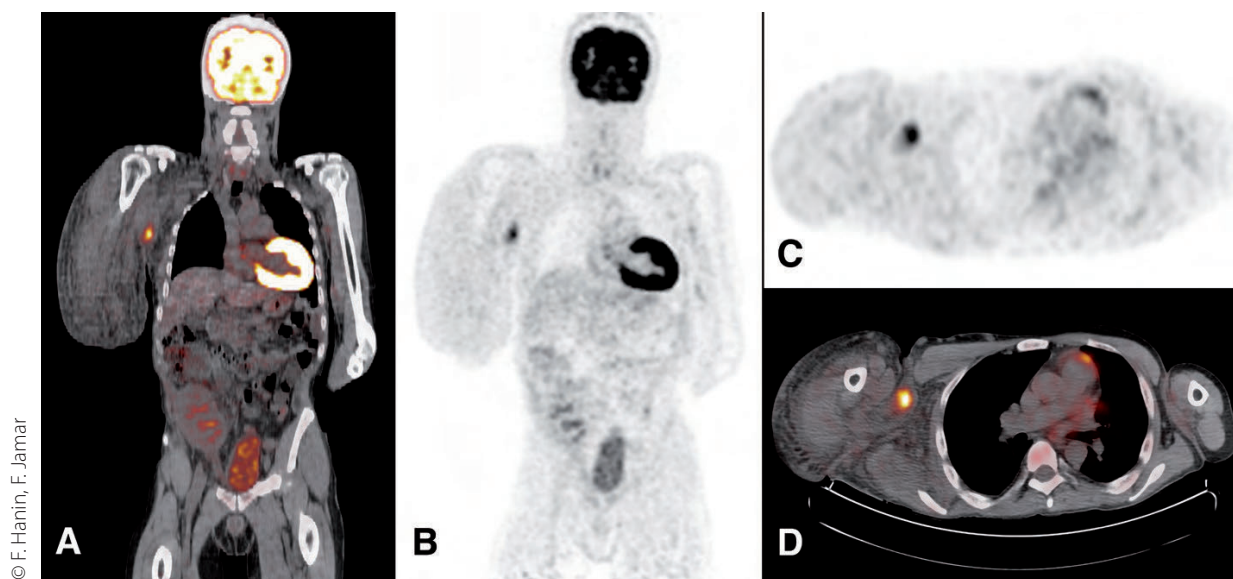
A 37-year-old patient with multiple vascular grafts showing multiple septic foci due to *Staphylococcus aureus*. Coronal (A, B) and axial (C, D) views of PET/CT fused images (A, D) and PET images (B, C) revealing focal uptake of FDG in the right axillary region, allowing accurate localization on the infected vascular graft
